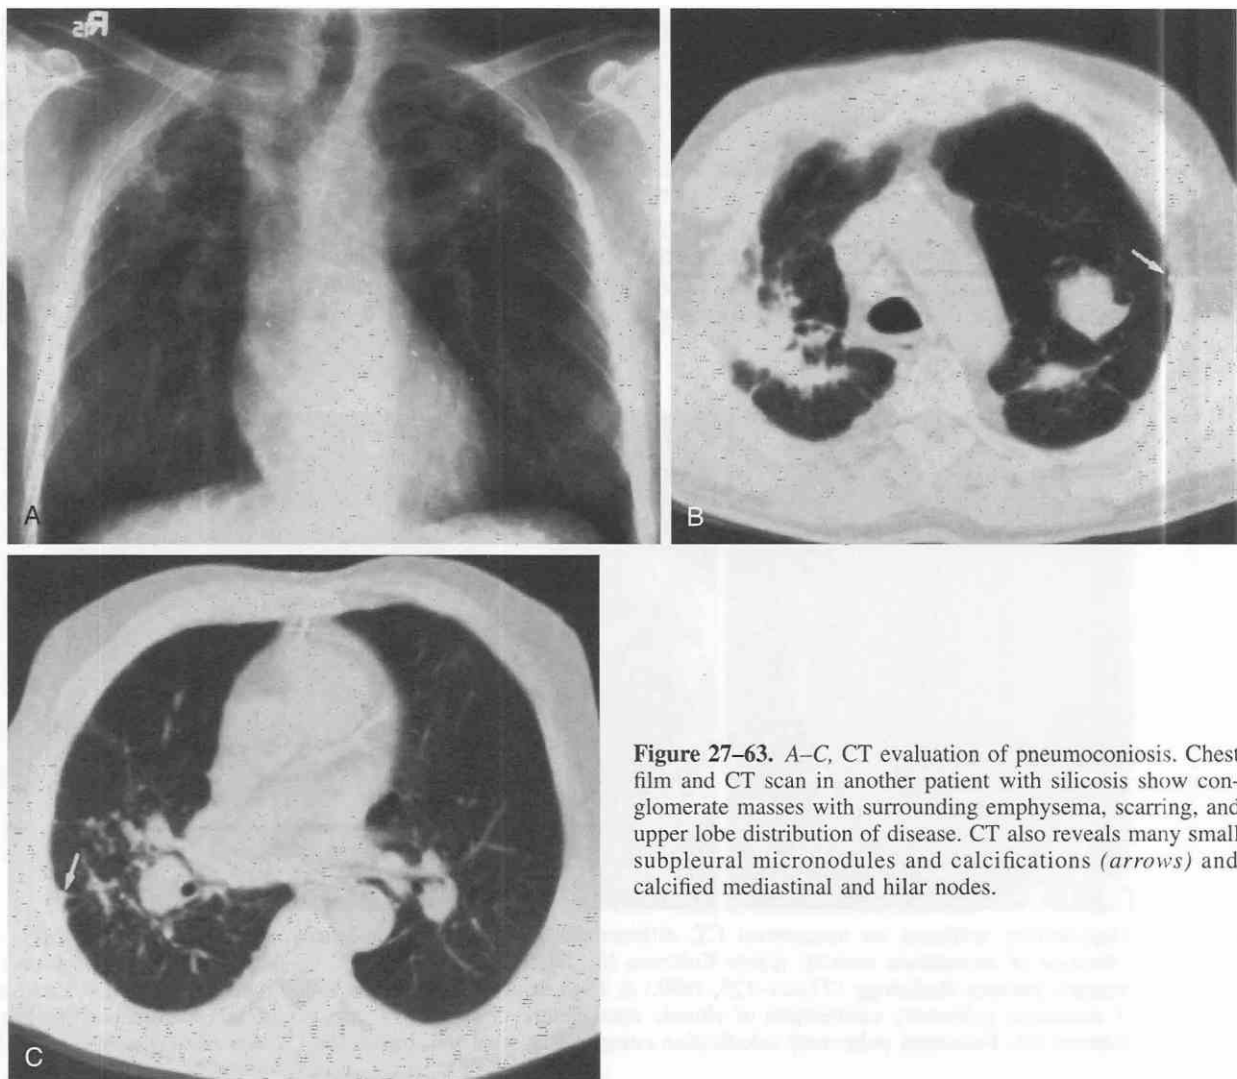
A-C, CT evaluation of pneumoconiosis. Chest film and CT scan in another patient with silicosis show conglomerate masses with surrounding emphysema, scarring, and upper lobe distribution of disease. CT also reveals many small subpleural micronodules and calcifications (arrows) and calcified mediastinal and hilar nodes.
